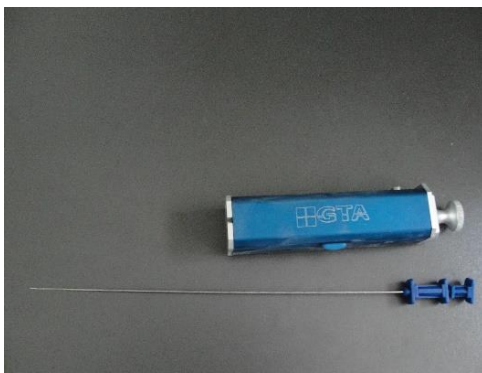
Automated GTA biopsy gun for ultrasound guided transcutaneous biopsies. Biopsy needle.
